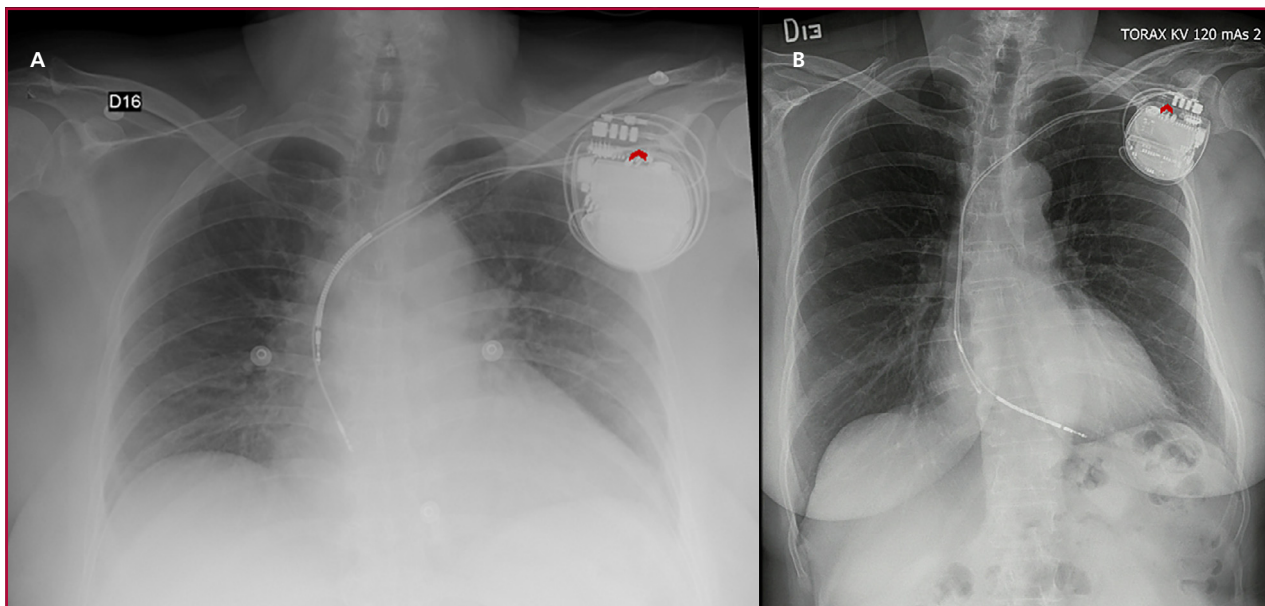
A. Initial chest X-ray upon arrival to the emergency room. Lead displacement is evident; the atrial lead is in traction in the right atrium and the ventricular lead is observed in the superior vena cava. Reel and ratchet syndromes are confirmed. The lead connectors are seen laterally directed (arrowhead), so a 180° rotation of the device in its sagittal axis is suspected. B. Chest x-ray in the immediate postoperative period after ICD implantation, five months before arrival at the emergency room. The lead connectors are seen medially directed (arrowhead).
